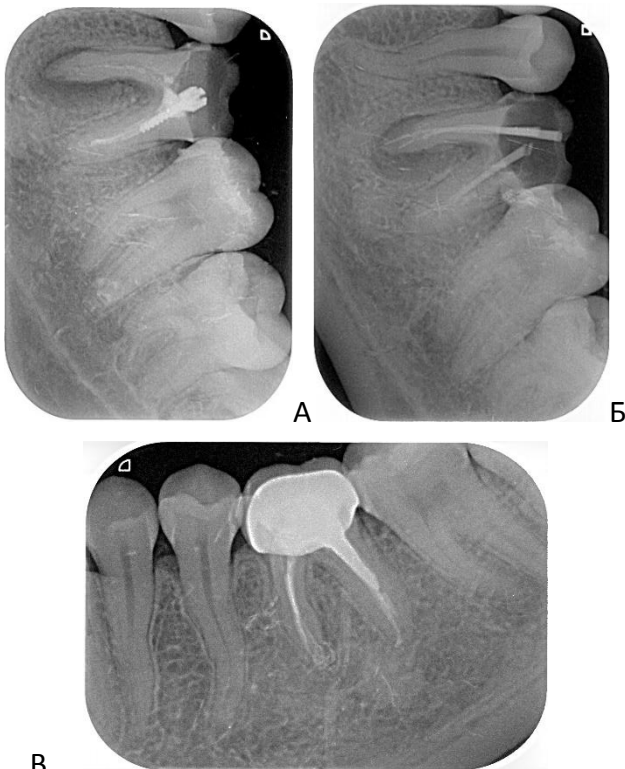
Patient M. radiogram of 46 tooth. Diagnosis: chronic granulomatous periodontitis: A – after treatment, Б – after treatment; B – 18 months after treatment. Considerable decrease of sizes of afflicted periapical tissues.
